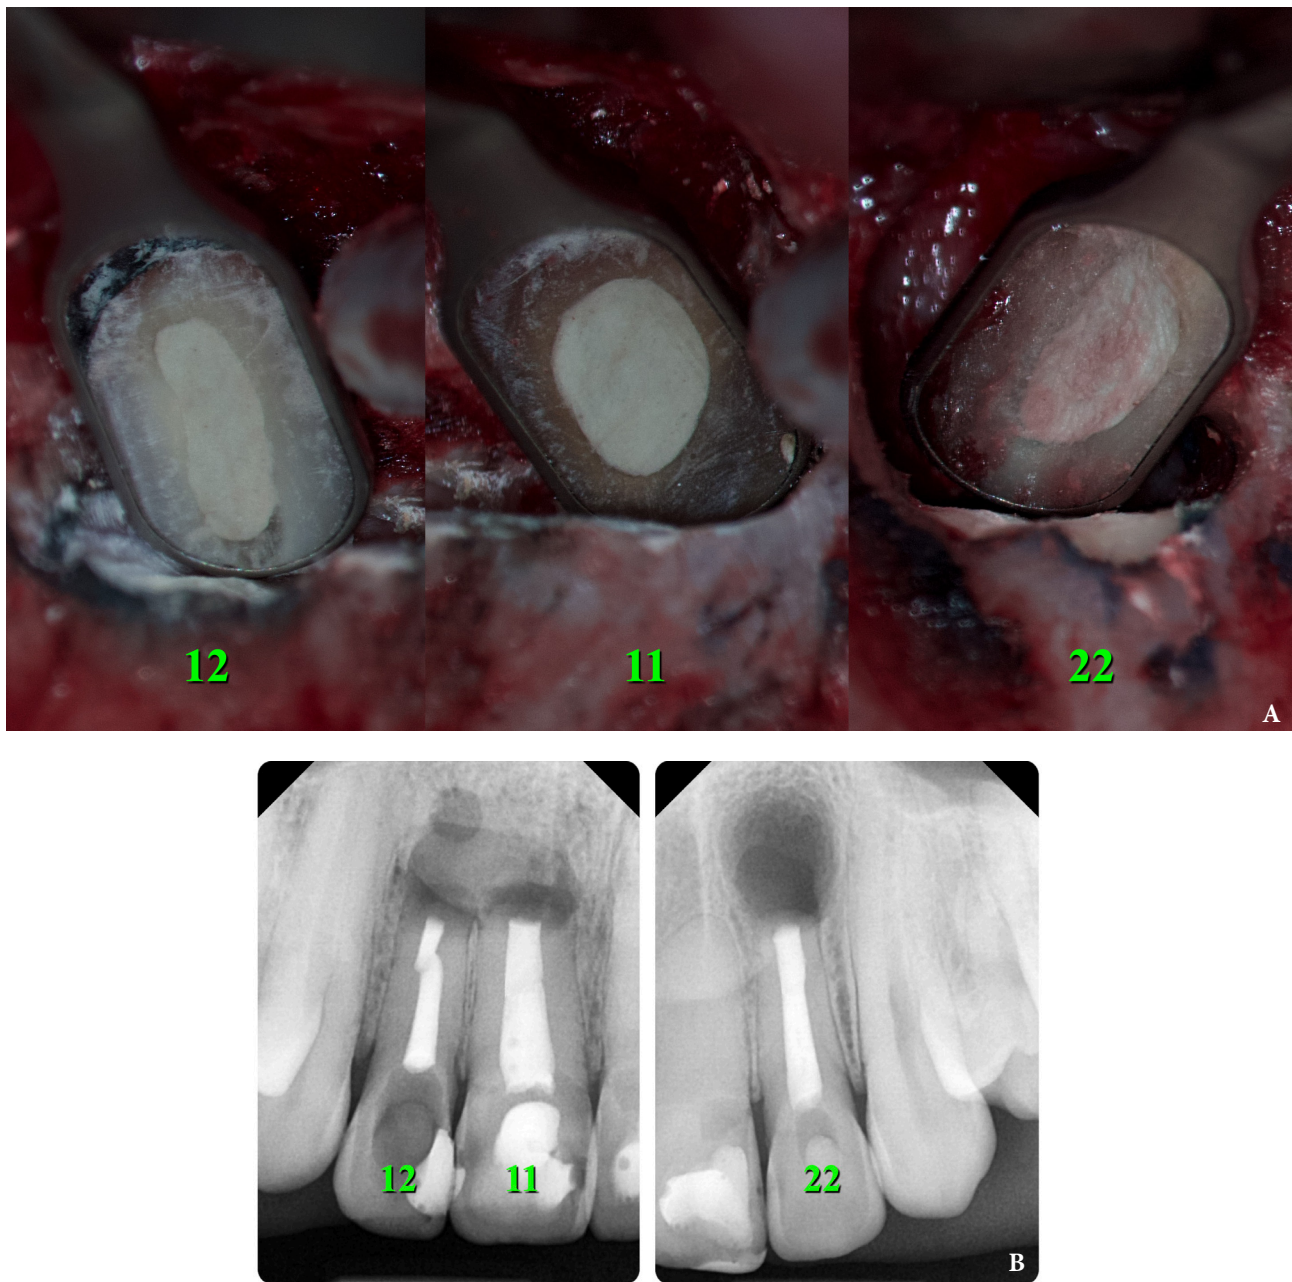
Retrograde filling with MTA (Bio MTA+, Cercamed) (A) and post-treatment x-ray (B). 12, upper right lateral incisor; 11, upper right central incisor; 22, upper left lateral incisor.
